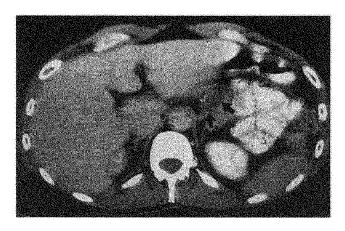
Case 2. CT scan demonstrating cystic tumor (arrows) in body of pancreas.
